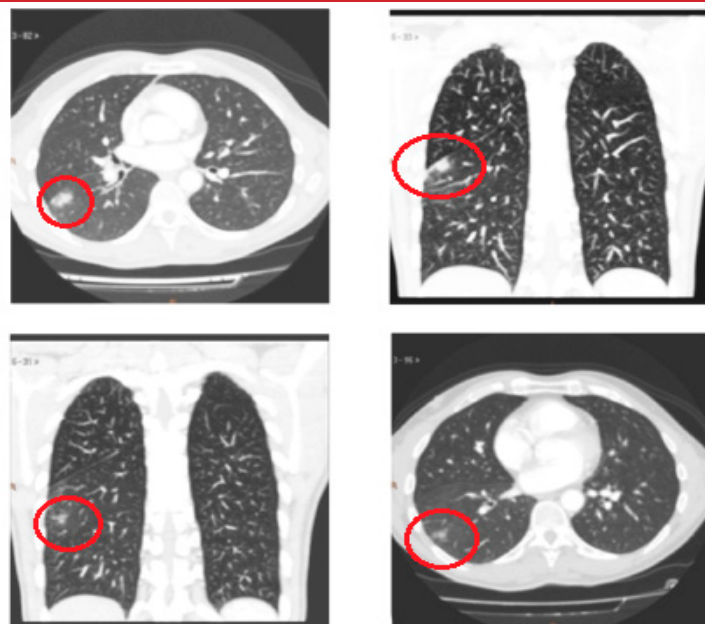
CT Scan slides showing pulmonary infiltrate (red circles)
